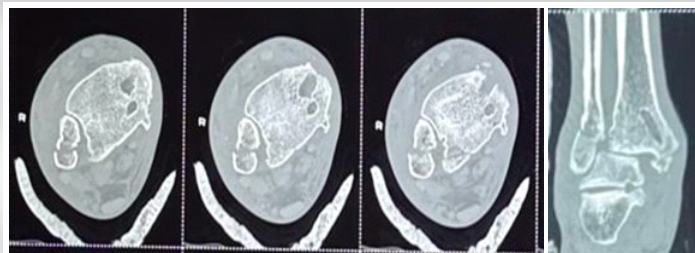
Computed tomography of ankle revealed dilated bone track in the tibia.
